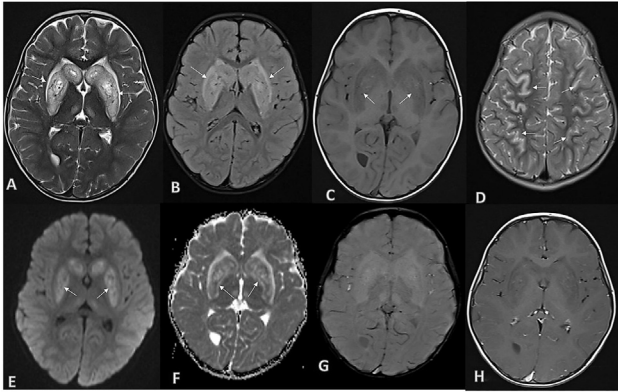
MRI revealed bilateral symmetrical high T2 (arrows in A) & coronal fluid-attenuated inversion recovery (FLAIR) (B) signal involving both basal ganglia (caudate and lentiform nuclei) which is swollen with central necrosis and involving bilateral medial thalami with T1 low peripheral and high central signal (C). Also, bilateral high frontoparietal cortical high T2 signal (arrows in D) with partial high signal in diffusion-weighted imaging (DWI) (E) and low signal in apparent diffusion coefficient (ADC) (F). No blooming foci on susceptibility weighted imaging (SWI) sequence (G) and no enhancement after IV contrast (H). It was confirmed by genetic as Biotin-thiamine-responsive basal ganglia disease with gene (*SLC19A3*) mutation.
